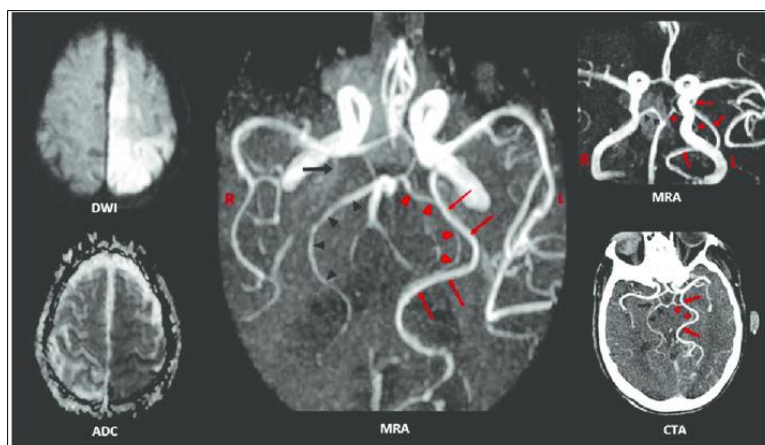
Acute infarcts in the left ACA, MCA, and PCA territories (hyperintense DWI, low ADC).
